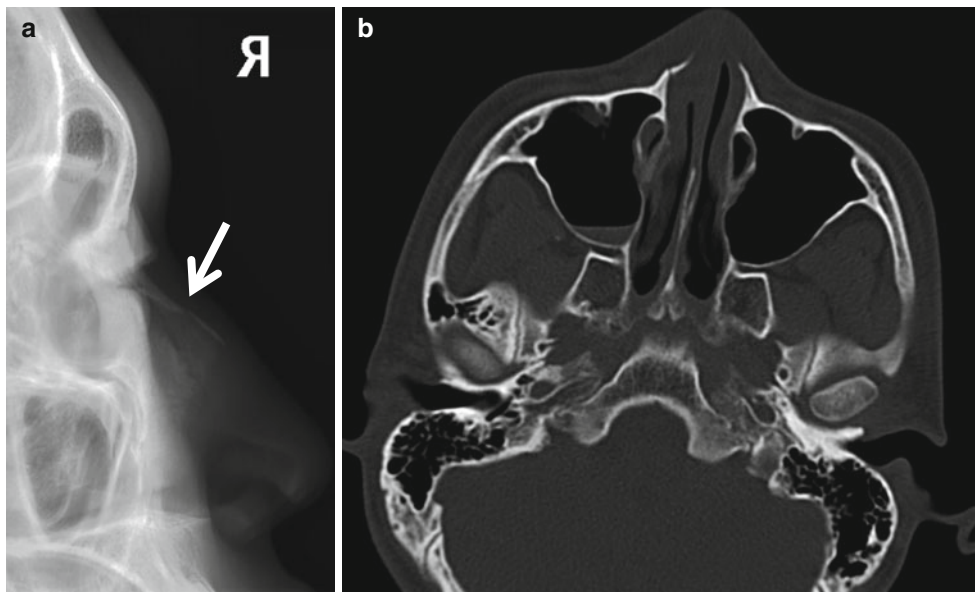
Nasal bone fracture. (a) Nasal bone lateral radiograph shows focal cortical disruption in the nasal bone (*arrow*). (b) Facial bone CT shows right nasal bone fracture with minimally displaced bone
